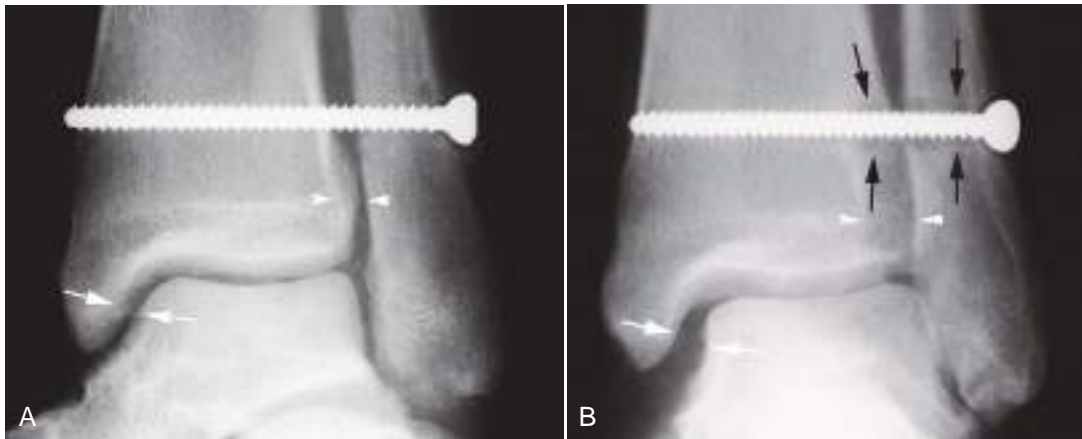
Hardware loosening. (A) Initial AP radiograph of the ankle shows an intact syndesmotomic screw fixing a distal tibiofibular diastasis injury. Note the normal alignment of the distal tibiofibular joint (*arrowheads*) and the medial ankle mortise (*arrows*). (B) Radiography repeated several weeks later shows bone resorption seen as lucency around the lateral aspect of the screw, especially in the fibula and lateral tibia (*black arrows*). Note the widening of the distal tibiofibular joint (*arrowheads*) and the medial mortise (*white arrows*). Infection or mechanical loosening could cause this appearance.
